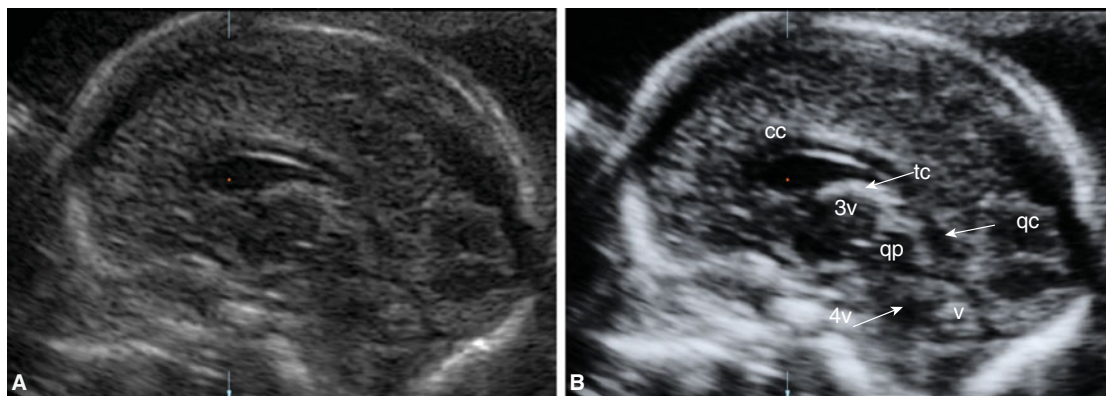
Sagittal view of the normal fetal head at 22 weeks of gestation. Comparison of two images obtained from the same ultrasound volume, using a standard plane mode (a) and with static volume contrast imaging with a thickness of 3 mm (b). Note the difference in resolution and contrast of the images, which allows better differentiation of different structures such as the corpus callosum (cc), tela choroidea (tc), quadrigeminal plate (qp), quadrigeminal cistern (qc), third ventricle (3v), fourth ventricle (4v), and vermis (v). The structures on (a) are identical to those marked on (b).
